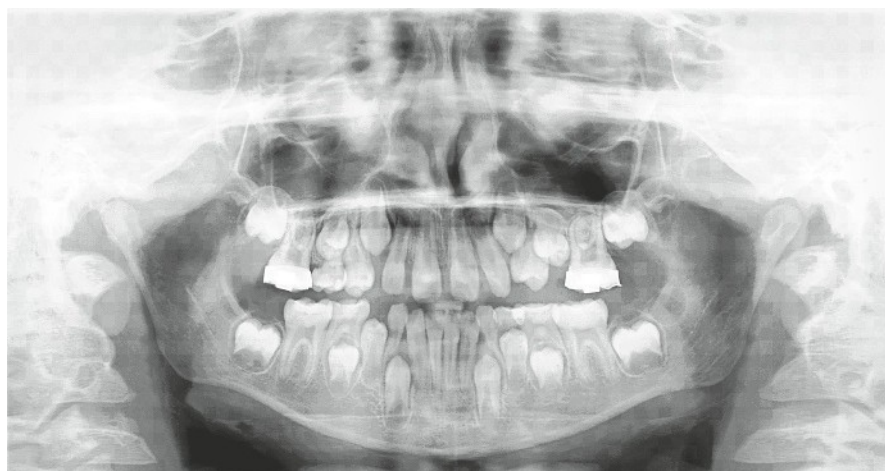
X-ray findings in 2012 before removal of the bands on the molars.
